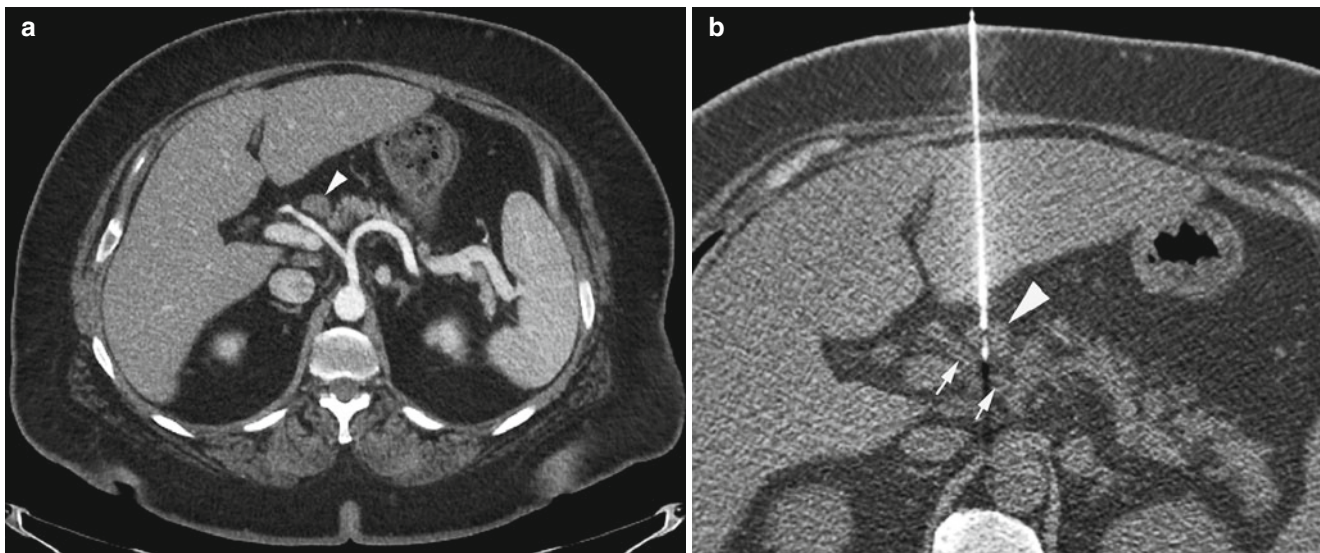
A morbidly obese, 55-year-old woman with endometrial cancer was found to have periportal lymphadenopathy. Diagnostic contrast-enhanced CT image of the abdomen (a) shows a 1.5 cm lymph node (*arrowhead*) immediately anterior to the common hepatic artery. Axial
